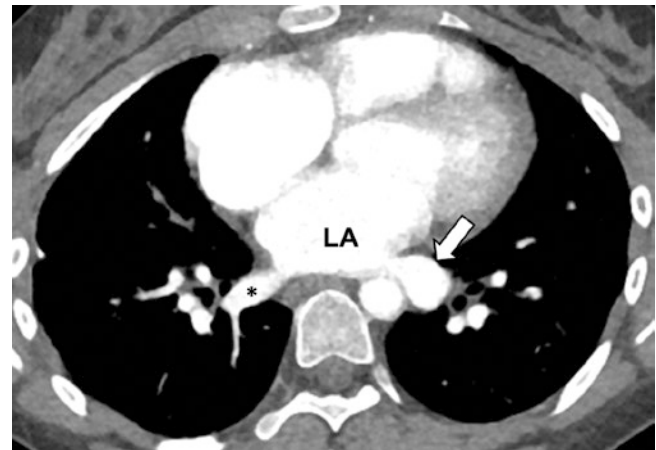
A 16-year-old girl who underwent CT study for evaluation of lung infection and an incidental detection of pulmonary varix. Enhanced axial CT image shows a dilated left inferior pulmonary vein (arrow). Normal-size right inferior pulmonary vein (asterisk) is also seen. LA = Left atrium
